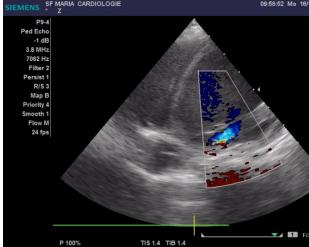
TTE Parasternal long axis view. Dilated left ventricle
